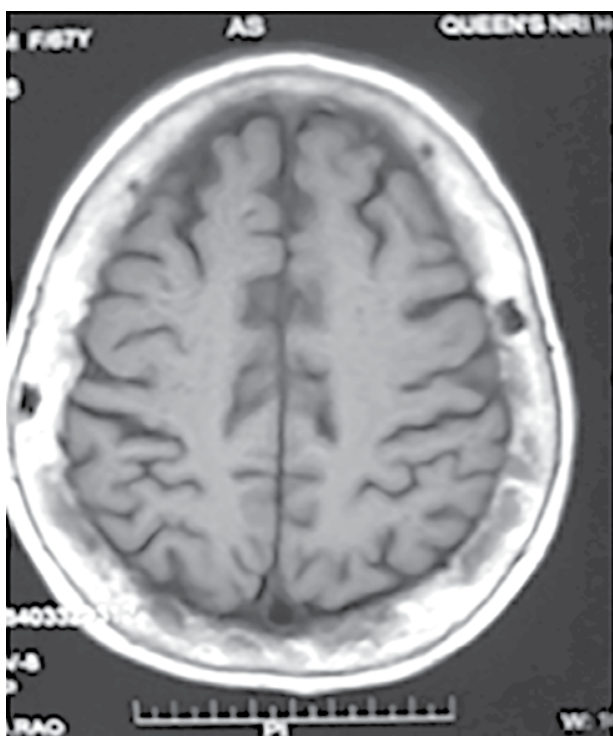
MRI skull showing enlargement, osteolytic and osteoblastic lesions.
